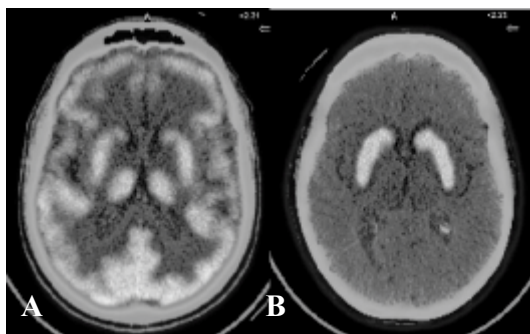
FDG-PET/CT scan in a normal control (A). Note uniform metabolic activity in cerebral cortices and deep grey matter. The F-DOPA scan (B) in this healthy patient shows intense uptake in the basal ganglia with minimal activity in the cortices.
